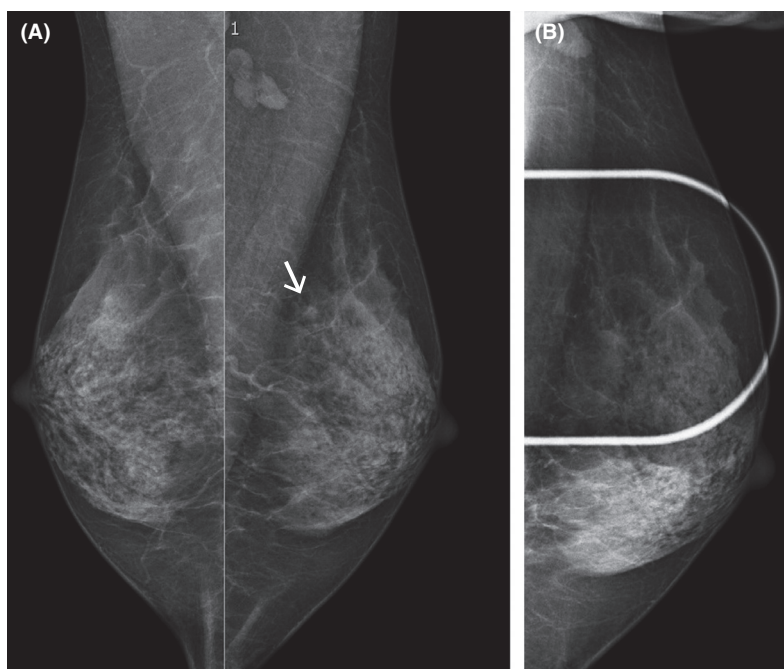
(A) Bilateral oblique mammograms (B) coned compression view left breast axillary projection. This 49-year-female with a strong family history of breast cancer was undergoing high-risk imaging surveillance with annual mammography and MRI studies. Her initial screening contrast enhanced MRI was normal. Nine months later a possible small mass (↓) was noted in the upper left breast on screening mammography (A). This resolved on the coned compression view (B). An extended CC view (not shown) was unremarkable.
